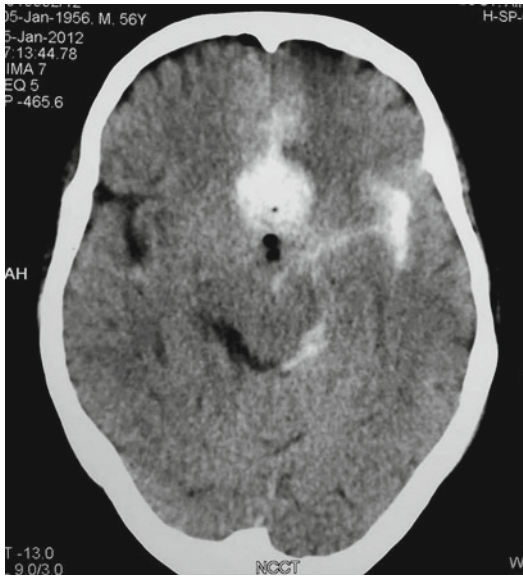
Postoperative CT scan of the patient reveals residual tumour with haematoma and subarachnoid haemorrhage in the right sylvian, perimesencephalic and interhemispheric fissures
